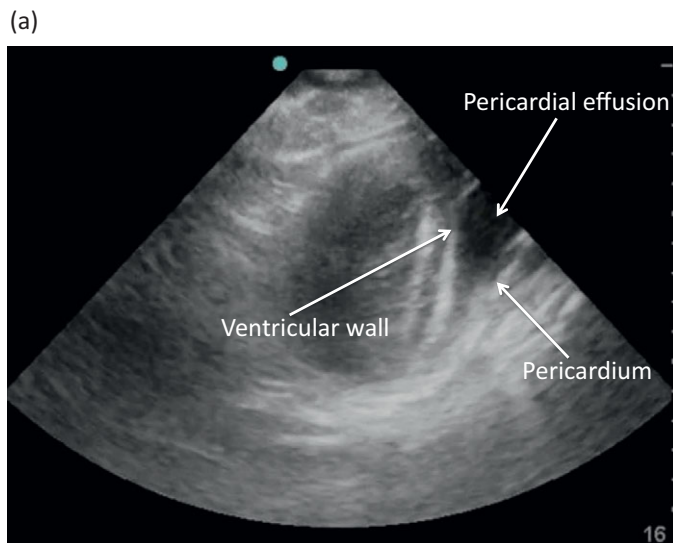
(a, b) Subxiphoid cardiac view obtained via FAST (Focused Assessment with Sonography for Trauma) exam demonstrating cardiac tamponade. Hypoechoic hemopericardium is visualized between the myocardium and pericardium.
